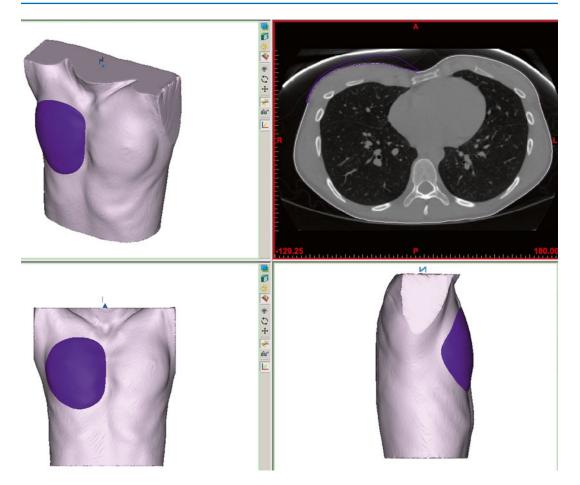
Another view of rendering of implant based on CT of patient presenting for pectoral augmentation
